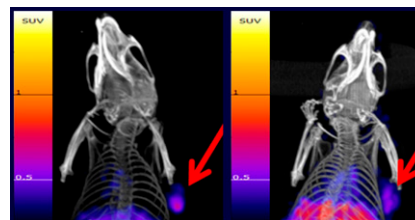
HER3-specific ^{64}Cu -DOTA-HER3-F(ab) 2 PET/CT imaging in (left) MDA-MB-468 and (right) HCC70 xenografts. Receptor cycling enables PET tumor visualization despite low HER3
